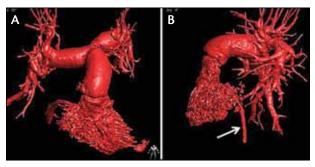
Segmentation to show the right ventricle and pulmonary artery. C-arm CT produced this 3D volume rendering and is displayed in two views. Note the reconstructed catheter entering the right ventricle from the inferior vena cava in the right panel (white arrow). This patient had a surgically placed conduit in the main pulmonary artery. Reproduced with kind permission from Springer Science+Business Media: Int J Cardiovasc Imaging, Potential role of three-dimensional rotational angiography and C-arm CT for valvular repair and implantation, 2011;27:1205–1222, Schwartz JG, Neubauer AM, Fagan TE, et al.²⁷
